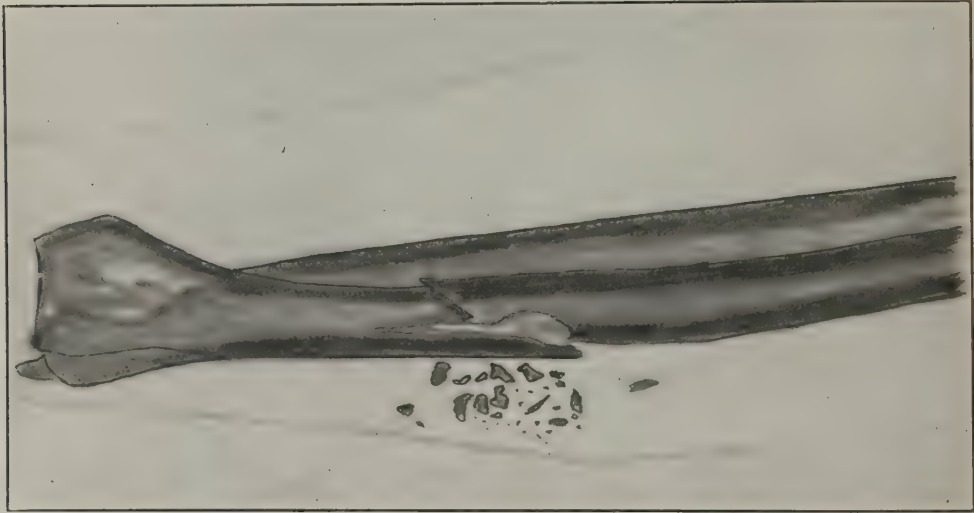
Outline of X-ray, Figure 167
